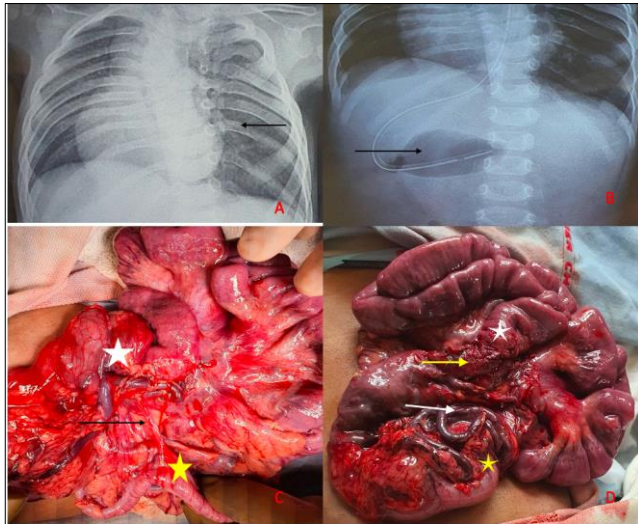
X-ray chest (A) showing thoraco-lumbar scoliosis with multiple costo-vertebral abnormality (black arrow). X-ray abdomen (B) showing stomach on the right side with nasogastric tube in-situ (black arrow). Intraoperative finding (C) showing Ladd's band (black arrow) between duodenojejunal junction (white star) and ileo-colic junction (yellow star) with dilated congested blood vessels (white arrow) and bowel after widening of mesentery (D) and division of Ladd's band (yellow arrow).
